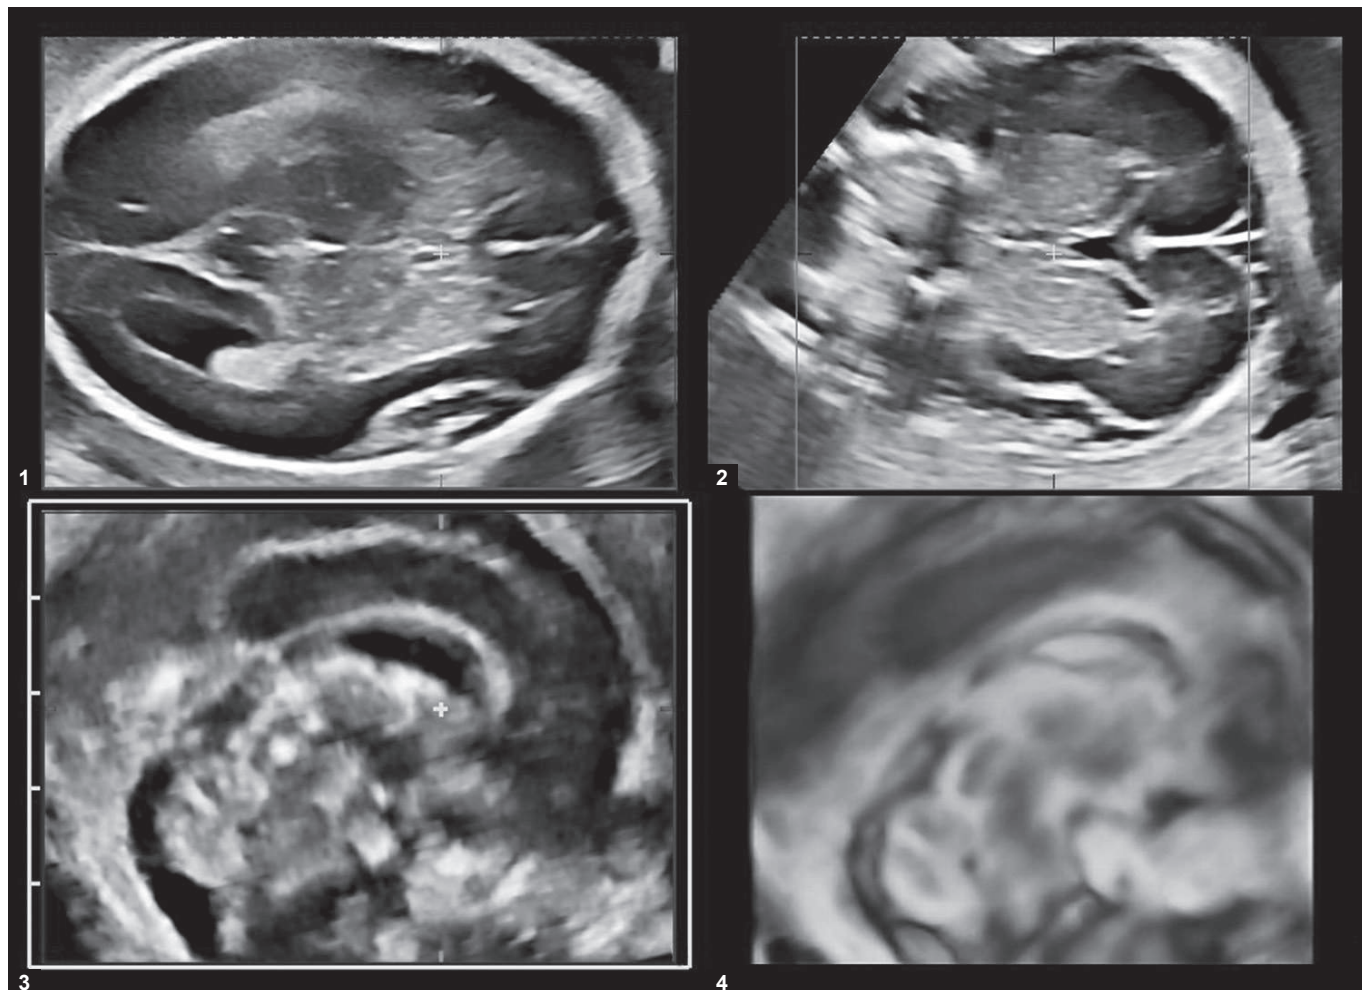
Three-dimensional (3D) ultrasound in the multiplanar mode. Plane 1 shows the volume acquired in the axial plane. The rendered coronal and sagittal sections are obtained in planes 2 and 3, respectively. The marker dot (yellow cross) is placed on the columns of the fornix. Note the loss of detail caused by near-field shadowing in plane 2. For color version, see Plate 1.
